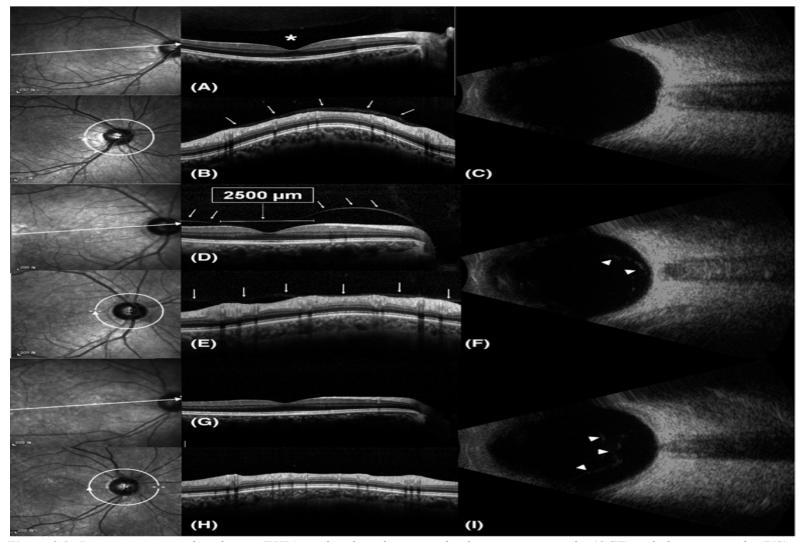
Posterior vitreous detachment (PVD) grading based on optical coherence tomography (OCT) and ultrasonography (US). (A–C) No PVD. (D–F) Partial PVD. (E–I) Complete PVD. Courtesy of Moon et al.¹⁷⁷
